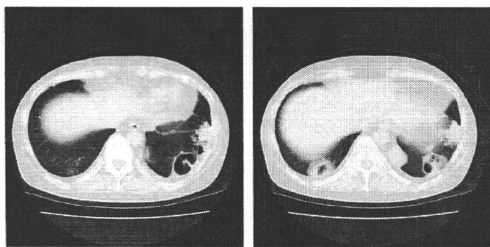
Chest computed tomography on February 20th, 2006. There is no pleurisy or pulmonary hemorrhage, but cavities can be observed in the bilateral lower lobes on February 20th, 2006.
